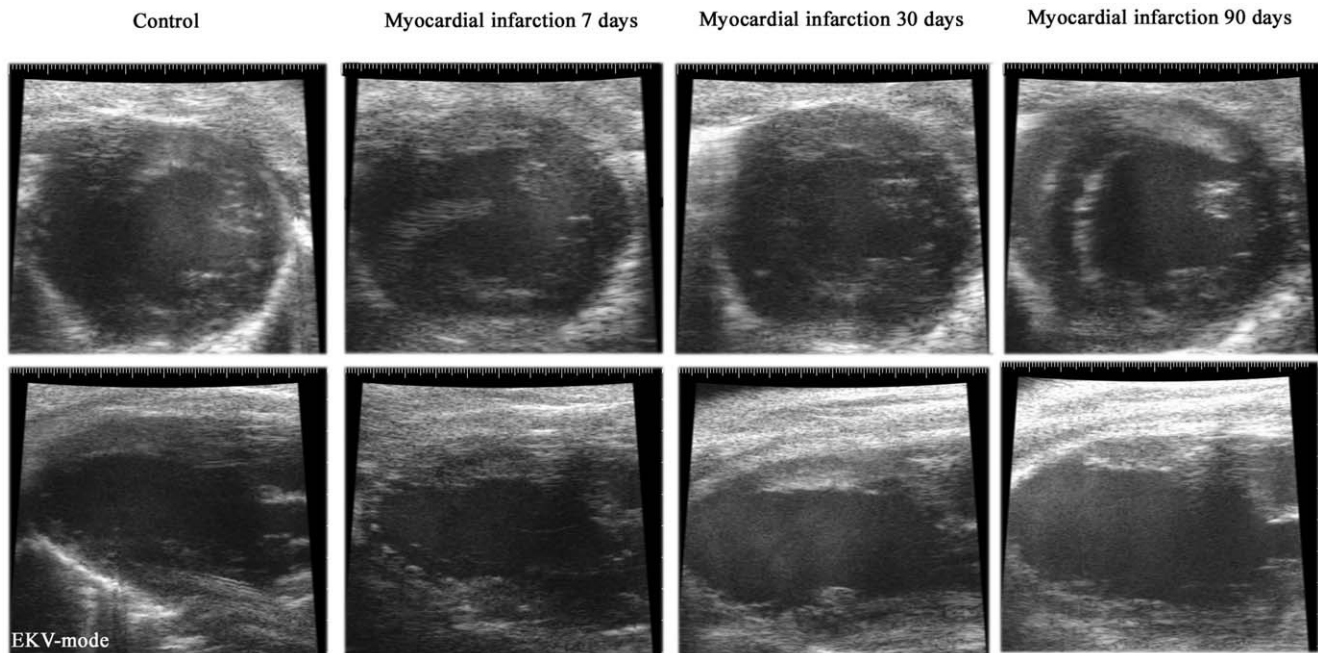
Visualization of the infarction. Sample EKV images at baseline and 7, 30 and 90 days post-infarction. Upper row: Parasternal short-axis views. Lower row: Parasternal long-axis views. The infarcted area is appreciated 7 days post-infarction and is located in the apical region. The evolution of the infarction results in progressive left ventricular remodeling. The videos from which the frames were selected are given as Supplementary material.
